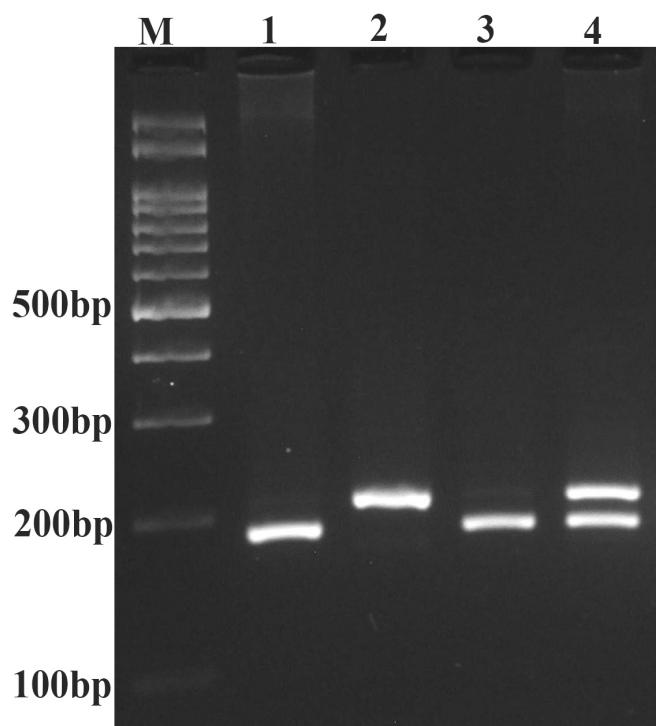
Photograph of the hsa-mir-603 rs11014002 C>T polymorphism using PCR-RFLP. The C allele was digested by HhaI restriction enzyme and produced 25-bp and 187-bp fragments, while the T allele was undigested (212-bp). M: DNA marker; Lanes 1 and 3: CC; Lane 2: TT; Lane 4: CT.
